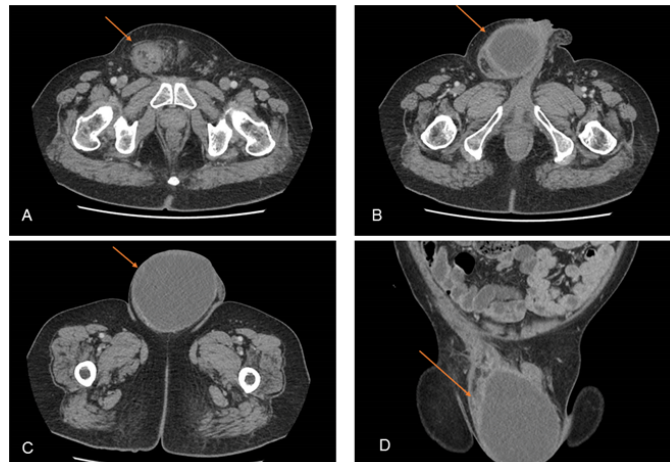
CT scan images (A-C axial view, D coronal view) showing diffuse thickening along the right spermatic cord and inguinal canal with a 12x9x10 cm collection compressing and displacing the penis and scrotal contents to the contralateral side. (arrows indicate the collection).
